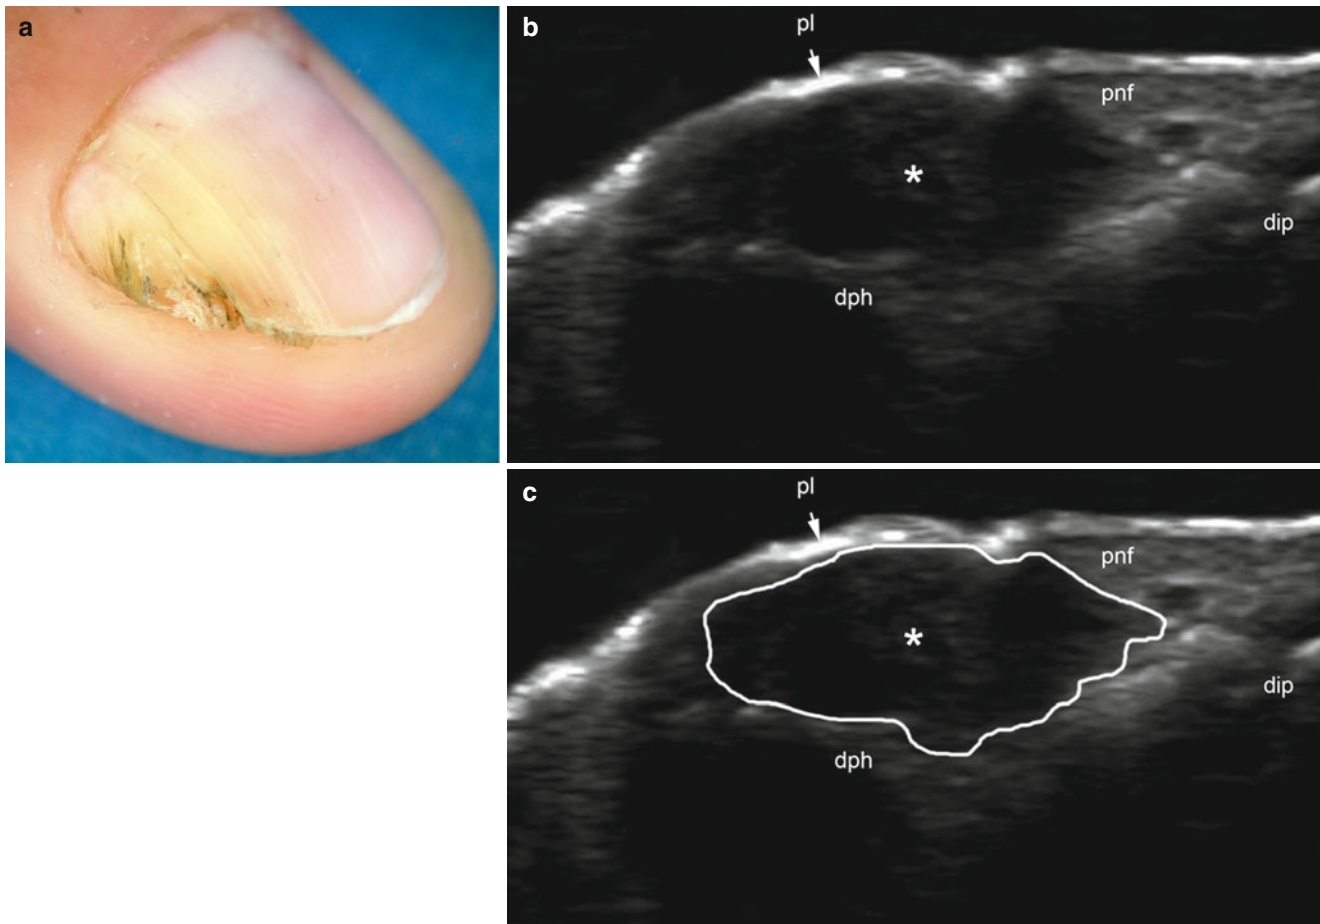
(a–c) Perineurioma. (a) Dermoscopy image shows a yellowish swelling and dystrophic changes in the radial aspect of the left middle finger (Courtesy of Dr. Veronica Catalan). (b, c) Grey scale ultrasound images (b longitudinal view, and c same view with the tumor outlined)
